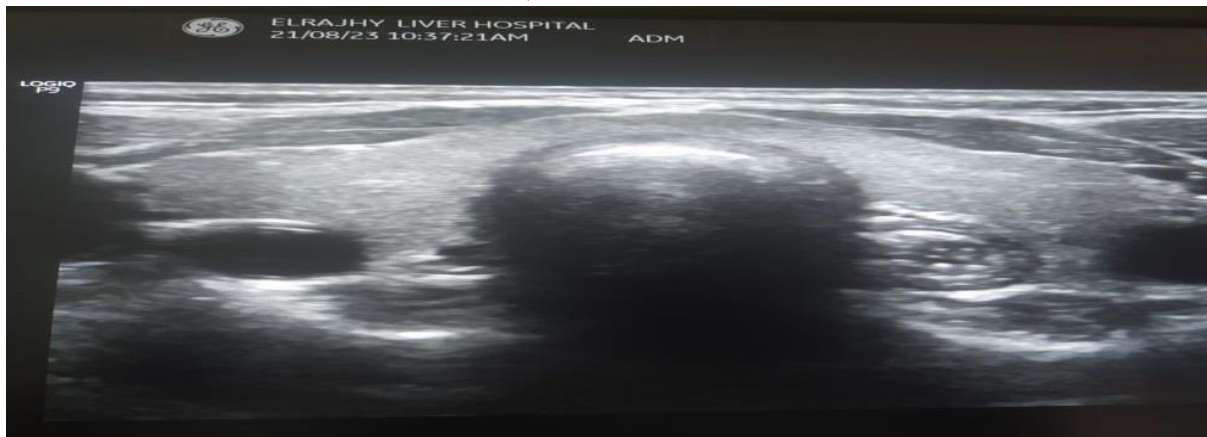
Normal thyroid ultrasound in patients with ulcerative colitis
